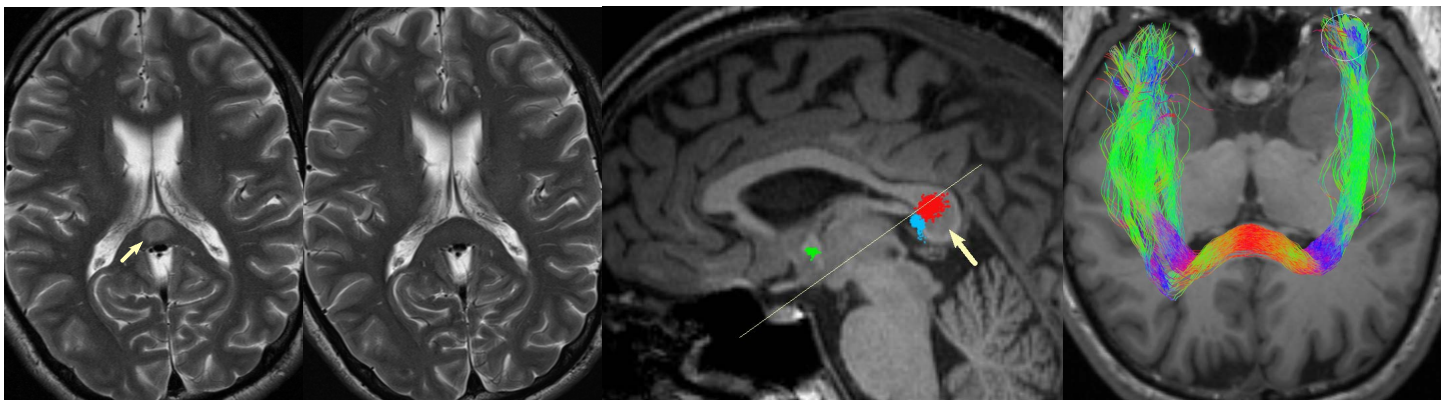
MRI of the described patient. a) Splenial lesion on T2-weighted imaging. b) Resolution of the lesion 6 months later. c) Midline sagittal T1-weighted image, with hypointense splenial lesion seen, showing tracks traversing the corpus callosum (red), hippocampal commissure (blue) and anterior commissure (green). Line indicates plane of figure 1d. d) Tracks from left temporal seed to right temporal target regions, which traverse the splenium, displayed on a co-registered T1-weighted image. Color indicates fibre direction.
